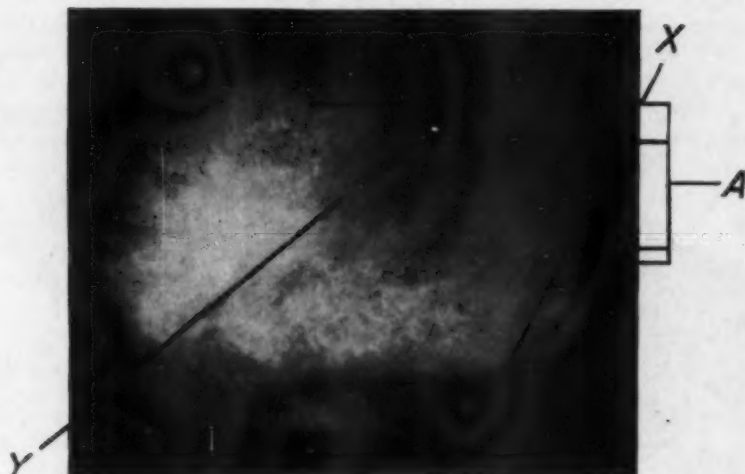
Roentgenogram of approximately half of the tumor mass. The other portions were removed in fragments. Note the density and irregularity of calcification. Several round structures resemble root cross sections (A). X and Y are the areas from which the sections of Figs. 8 and 10 were taken. (Pl. 8314.)
